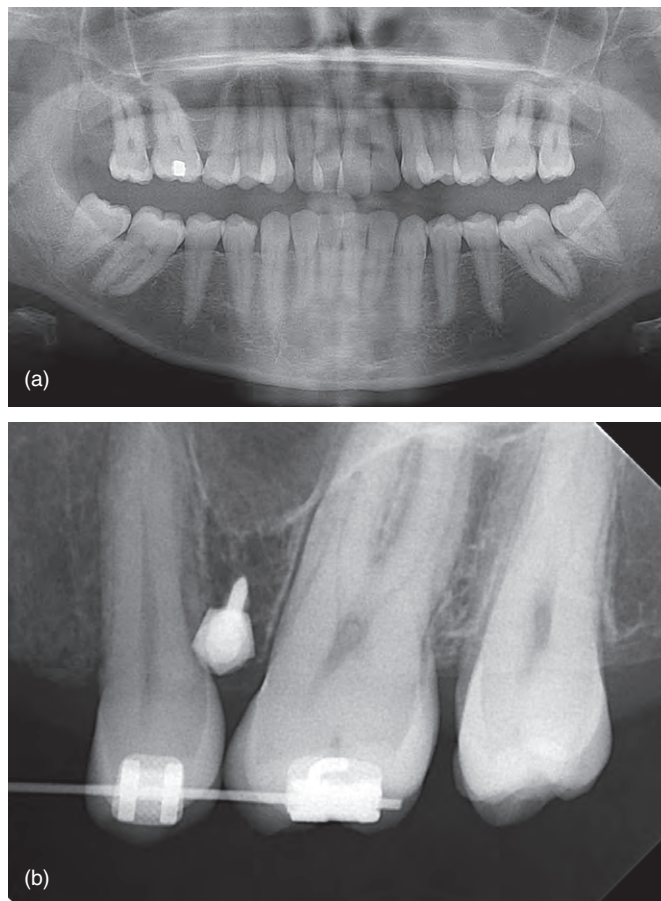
(a) Pre-treatment panoramic and (b) intra-oral post-insertion radiographs of an adult with early loss of all first molars. The maxillary sinus floor is at a relatively coronal level bilaterally, which limits the vertical (apical) level of mini-implant insertion.
